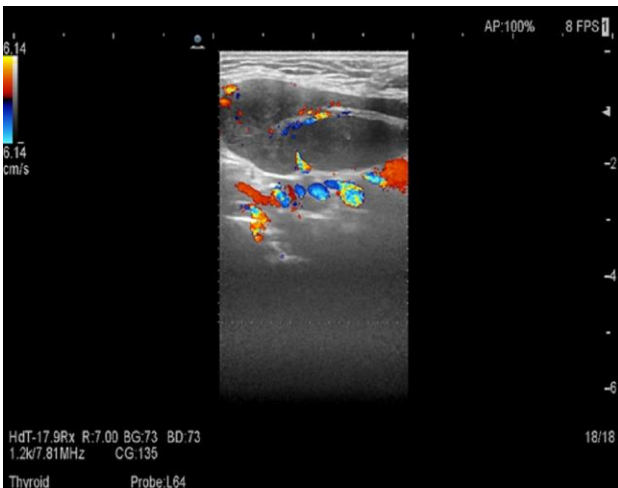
Colour doppler image of relative vascularity of lymph node.
